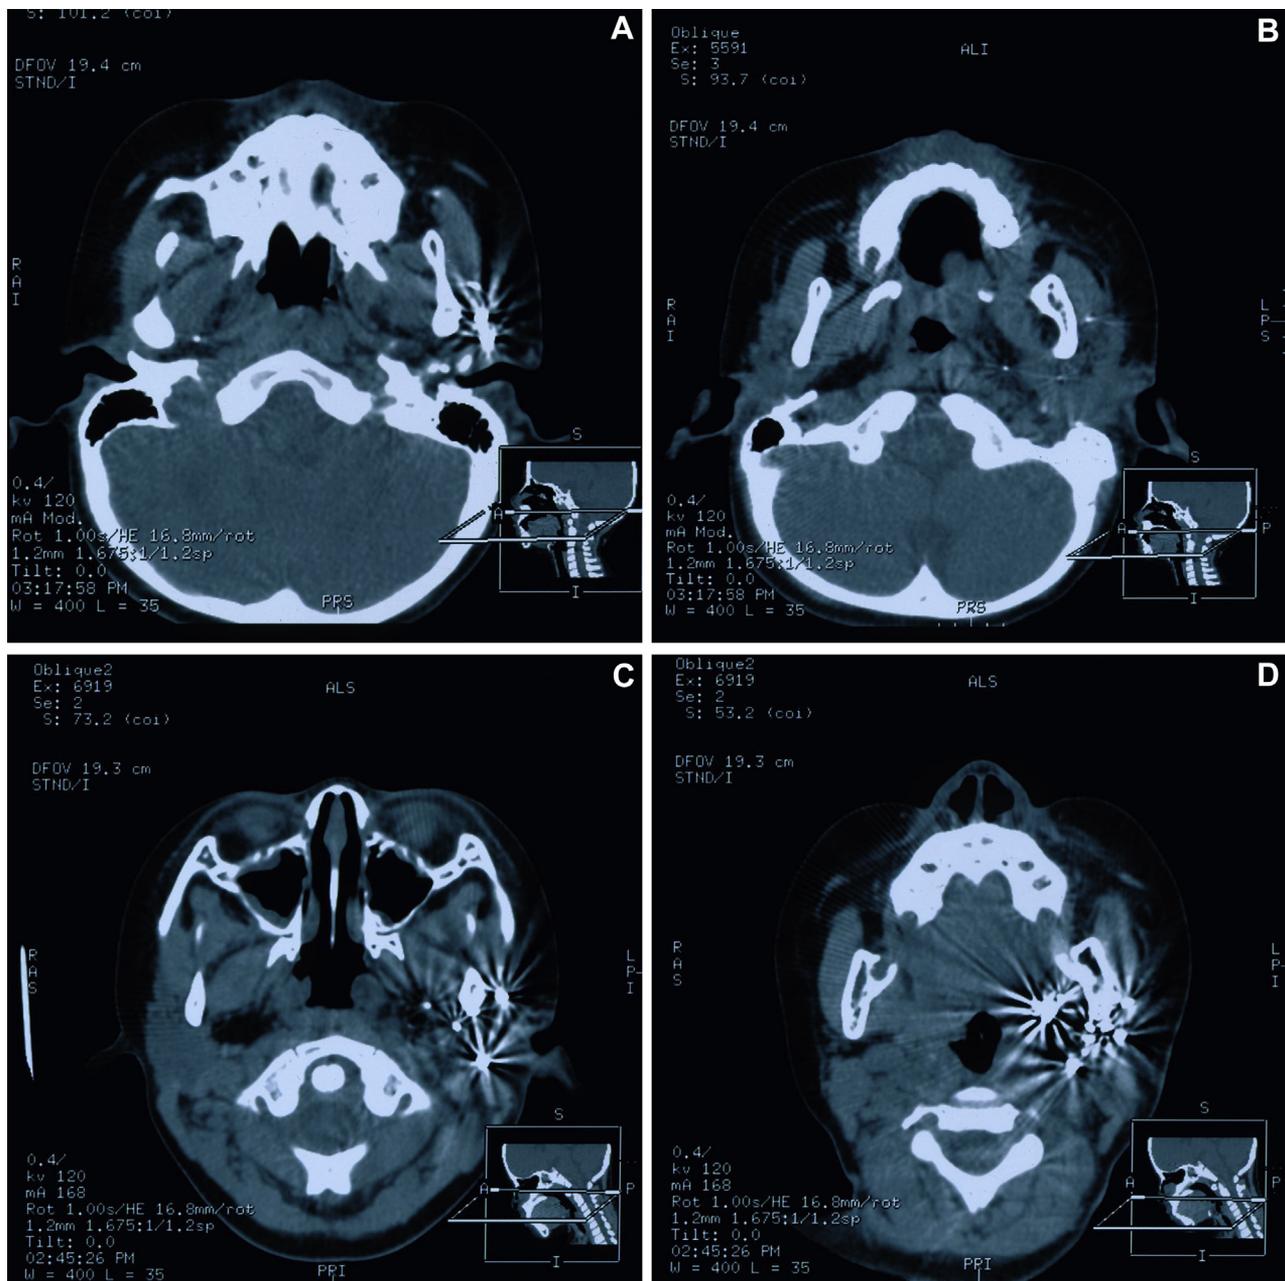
A, B, Two months after brachytherapy, computed tomograms show tumor regression and a wider pharyngeal cavity. C, D, Six months after brachytherapy, computed tomograms show no tumor and an almost normal oropharyngeal cavity.
